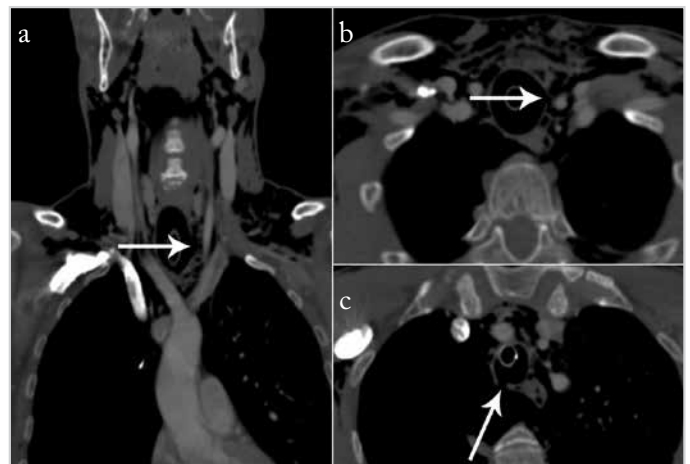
a-c. (a) Neck–chest computed tomography angiography. Left tracheal wall injury (Arrow) with penetration through the subcutaneous tissue and muscular plane. (b) Neck–chest CT angiography showing tracheal perforation (arrow). (c) Right posterior tracheal wall lesion corresponding to the stab output path (arrow)
